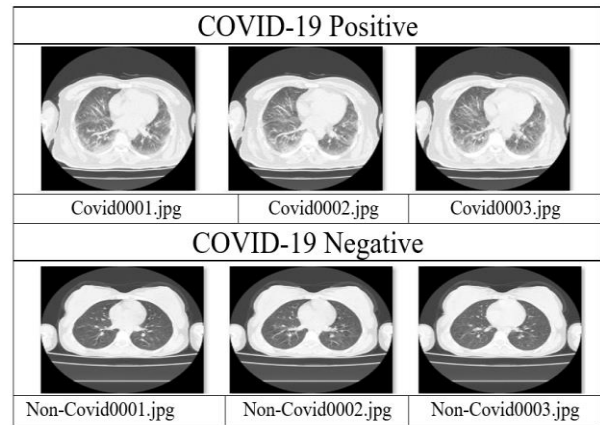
CT images of COVID-19 Positive and COVID-19 Negative people
